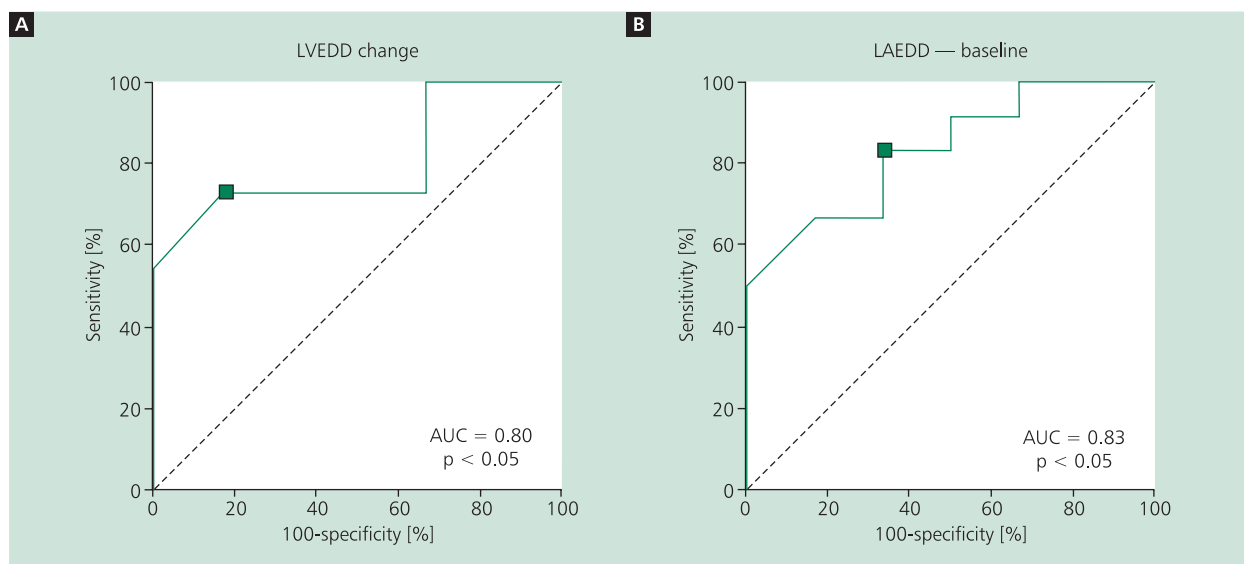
Receiver operating characteristics analysis of echocardiographic parameters in prediction of matrix metalloproteinase-9 (MMP-9) serum level decrease after cardiac resynchronisation therapy (CRT); A. Left ventricular end-diastolic diameter (LVEDD) change in prediction of MMP-9 serum level decrease during CRT; B. Left atrial end-diastolic diameter (LAEDD) at baseline in prediction of MMP-9 serum level decrease during CRT; AUC — area under curve
